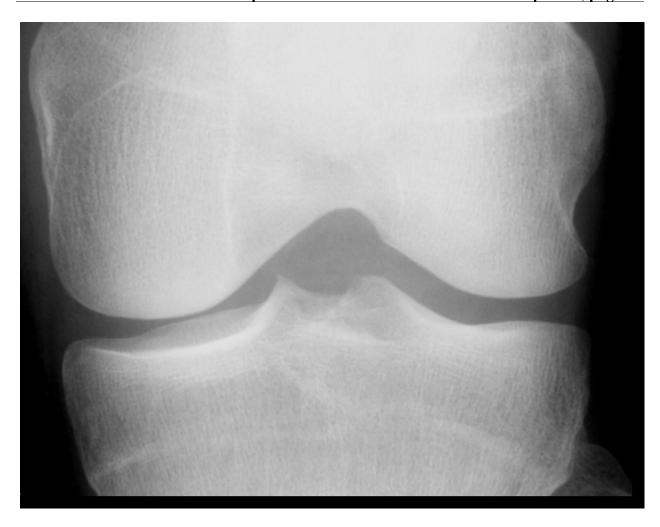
Example of a knee radiograph where the medial tibial plateau is unacceptable
